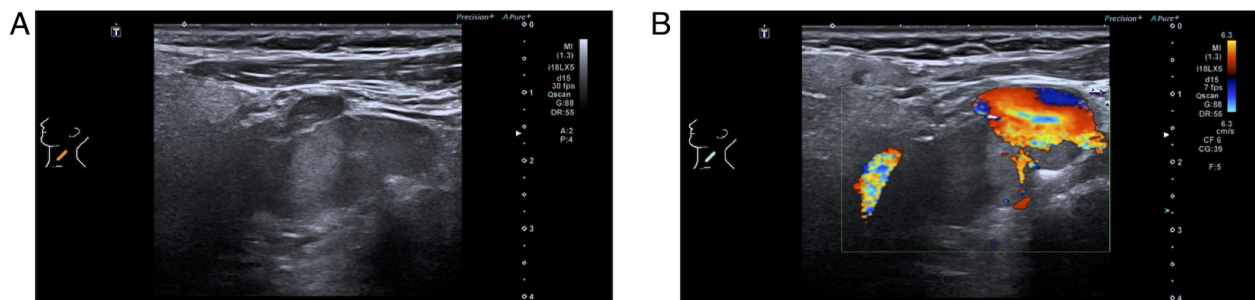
Preoperative color Doppler ultrasound of the salivary glands and draining lymph nodes. (A) Irregular hypoechoic mass in the left submandibular area, with (B) sparse blood flow signals around and within the lesion.
